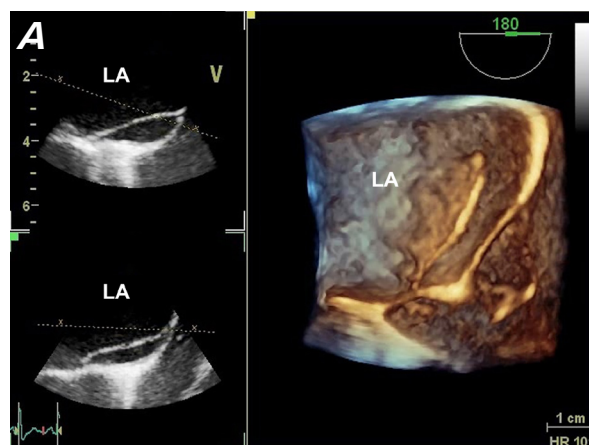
Three-dimensional transesophageal echocardiograms in A) modified midesophageal long-axis and B) midesophageal views show 2 parallel interatrial septa enclosing an additional interatrial chamber (arrows).
